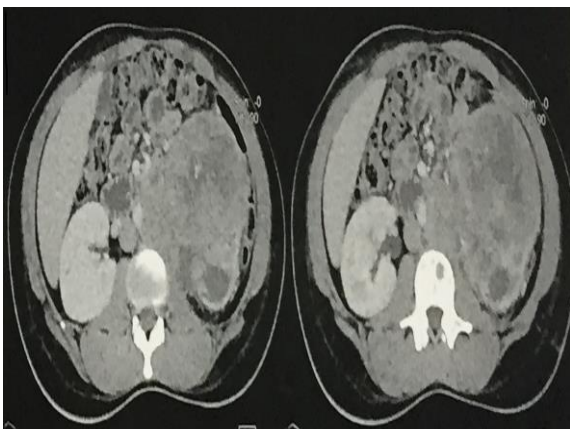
CT-scan axial image of the left kidney tumor
